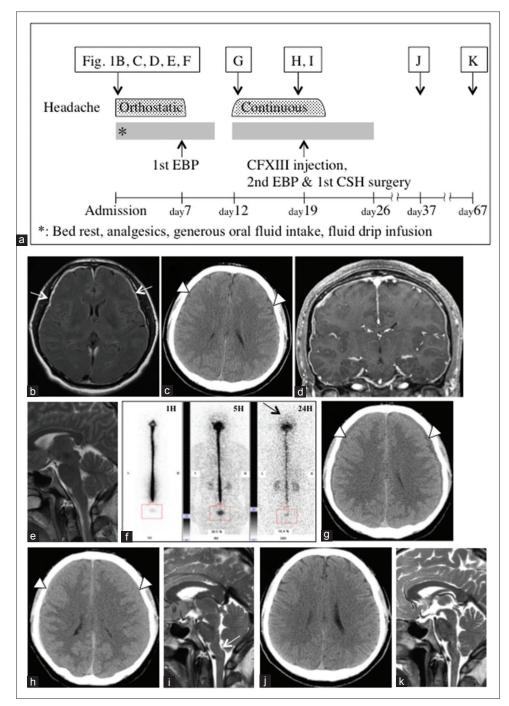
(a) Clinical course. (b) MRI with FLAIR on admission showed thin chronic subdural hematomas (CSHs) on both sides (white arrows). (c) Axial CT depicted bilateral thin CSHs. (d) Coronal TI-weighted MRI with gadolinium showed diffuse meningeal enhancement. (e) No displacement of the brain stem was seen on the mid-sagittal T2-weighted MRI. (f) Although RI cisternography 1, 5, and 24 h after intrathecal injection of RI revealed no apparent cerebrospinal fluid leakage, no visualization of RI activity over the cerebral convexities was seen even after 24 h. (g) Axial CT scan on the 5th day after EBP demonstrated that the CSHs were slightly increased in size. (h) Axial CT scan on the 12th day after the first EBP depicted that the thin CSHs had apparently increased. (i) Mid-sagittalT2-weighted MRI on the 12th day after the first EBP showed backward displacement of the brain stem. (j) Axial CT scan on the 18th day after the second treatment revealed complete disappearance of the CSHs. (k) Disappearance of the brain stem displacement was seen on mid-sagittal T2-weighted MRI on the 48th day after the second treatment. Abbreviations within figure: EBP, epidural blood patch; CFXIII, coagulation factor XIII; CSH, chronic subdural hematoma
